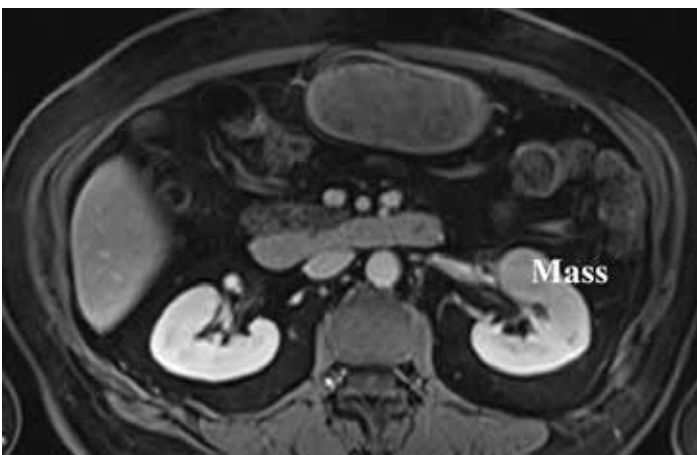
Magnetic resonance image of left renal mass
